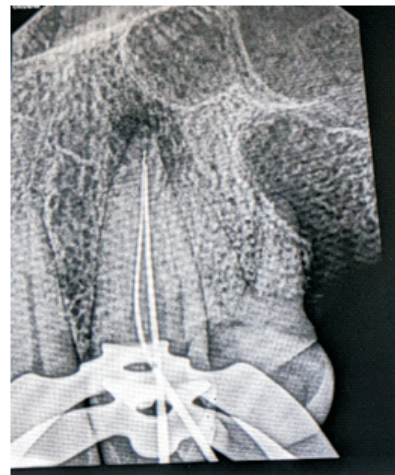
Working length radiograph showing 15k file in the buccal and 10k file in the palatal canal
